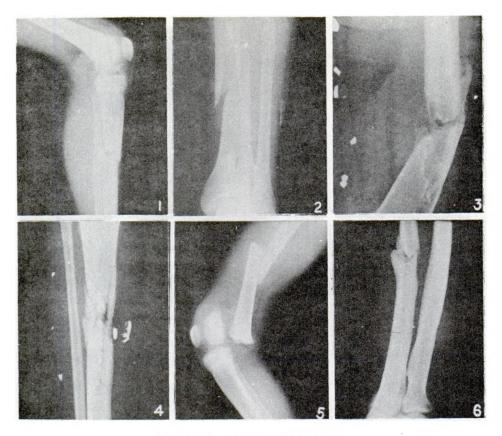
X-rays of fractures.
